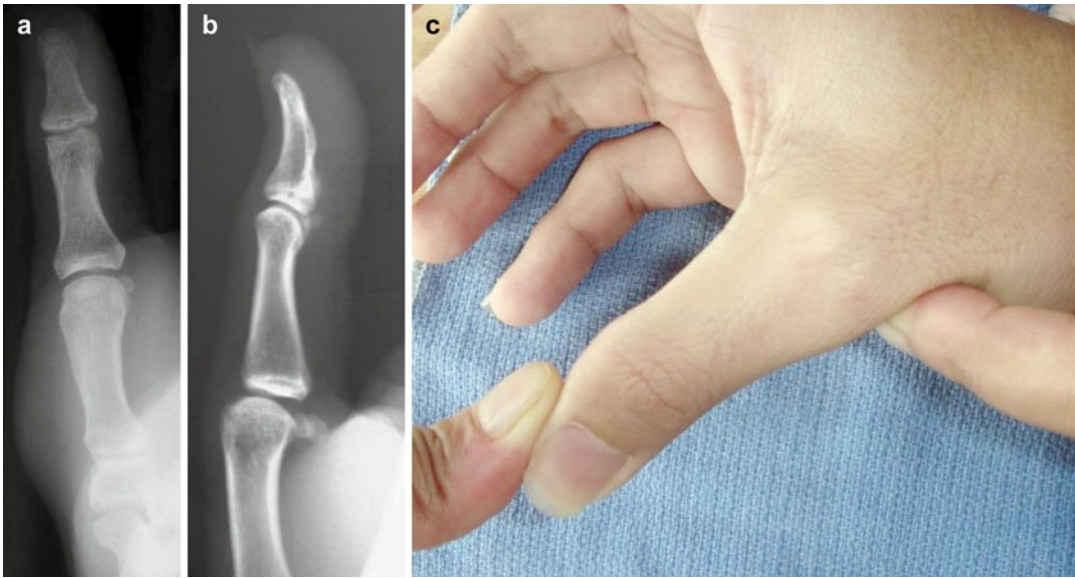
Patient in Fig. 15.33a. (a) AP and (b) Lateral radiographs of a patient with a UCL rupture. Very minimal opening up of the ulnar side of the joint but significant
